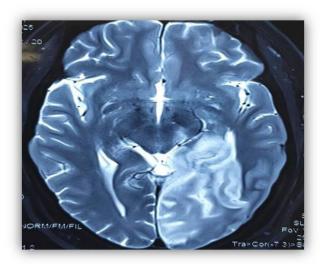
T2-Weighted axial MRI of the brain showing thalamic and occipital structures
